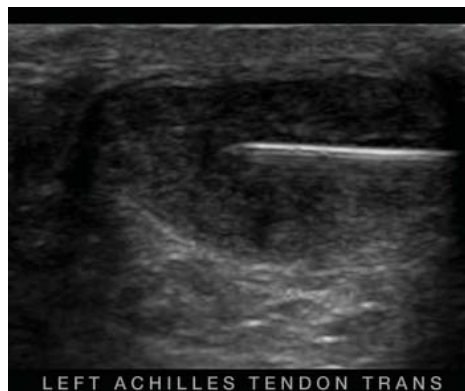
Ultrasound guided autologous blood injection of Achilles tendinopathy.
